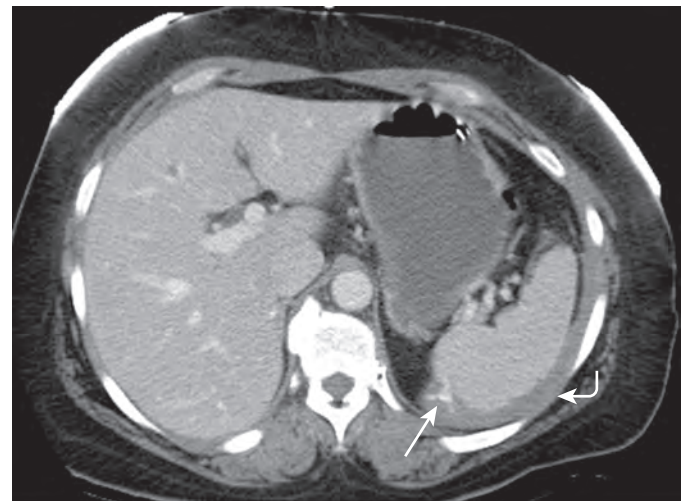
Splenic injury with active extravasation. A 45-year-old woman who was involved in a motor vehicle collision. Contrast-enhanced CT of the abdomen reveals a splenic injury with hemorrhage adjacent to the spleen (curved arrow) and an area of active extravasation (straight arrow). Splenic injury with active bleeding was confirmed at exploratory laparotomy with subsequent splenectomy.
